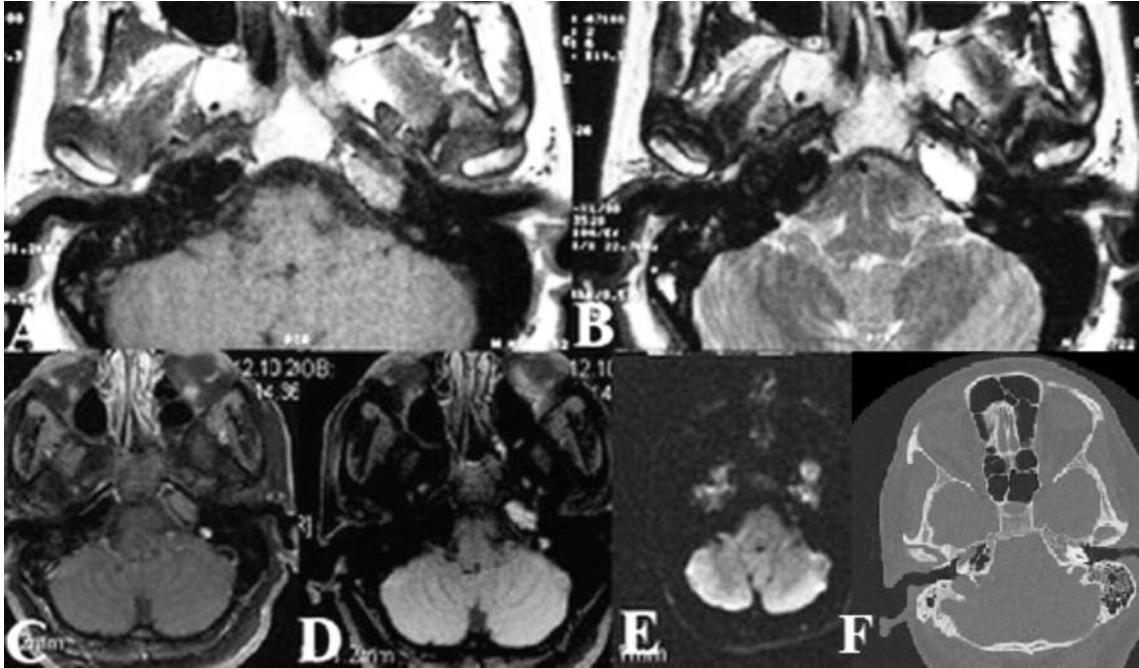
Entrapped fluid centered in the left PA. A: Axial T1 WI shows an isointense lesion; B: Axial T2 WI shows a hyperintense lesion; C: Axial T1 WI with contrast shows no enhancement; D: FLAIR shows an isointense lesion with hyperintense area; E: DWI shows no diffusion restriction; F: Axial CT shows isodense lesion without expansion and destruction of trabeculae.
